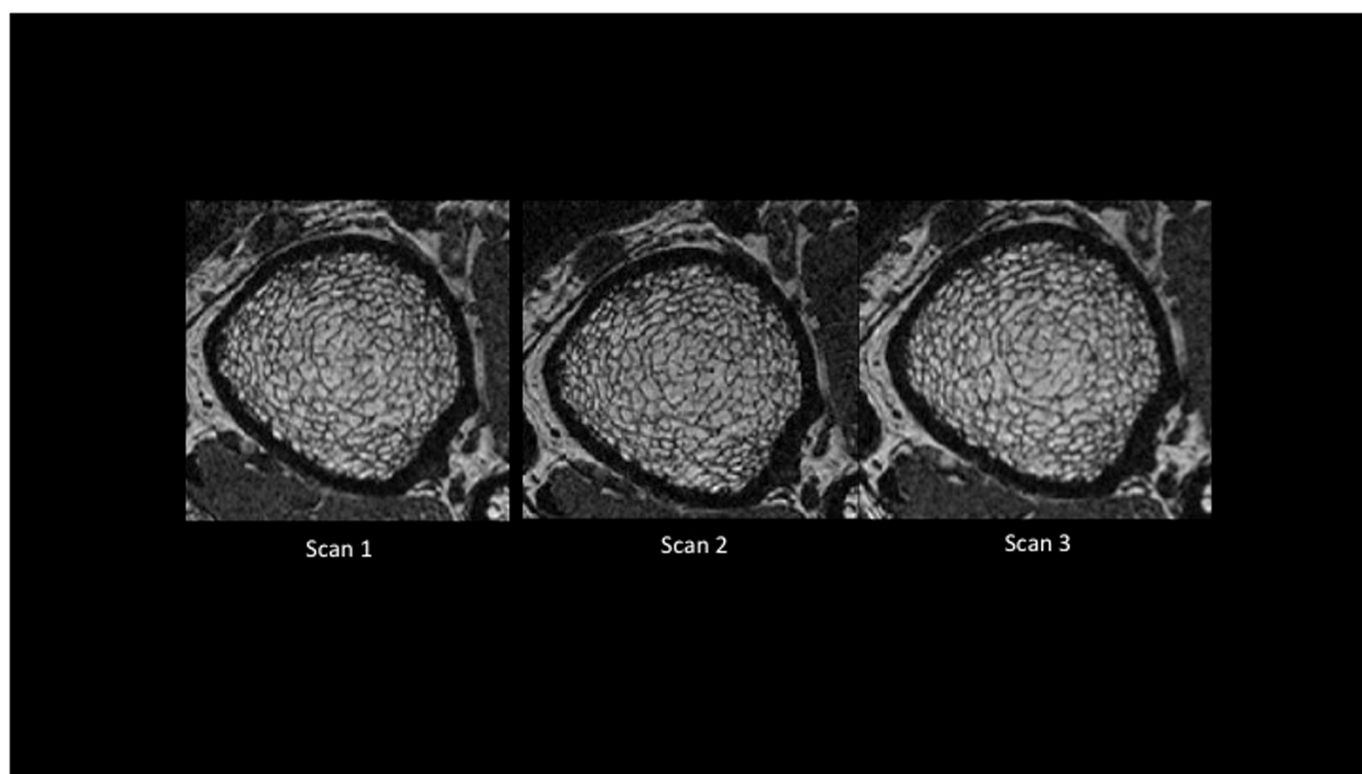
Repeat images from one participant. Note the visual similarities among all three MRI scans.
